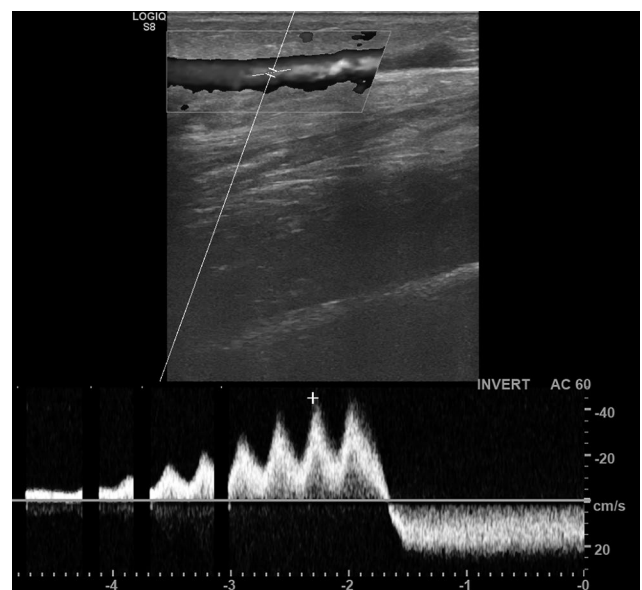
Real-time Doppler ultrasonography of a below-the-knee segment of great saphenous vein demonstrating venous insufficiency as flow reversal lasting >0.5 sec during provocation maneuvers.
